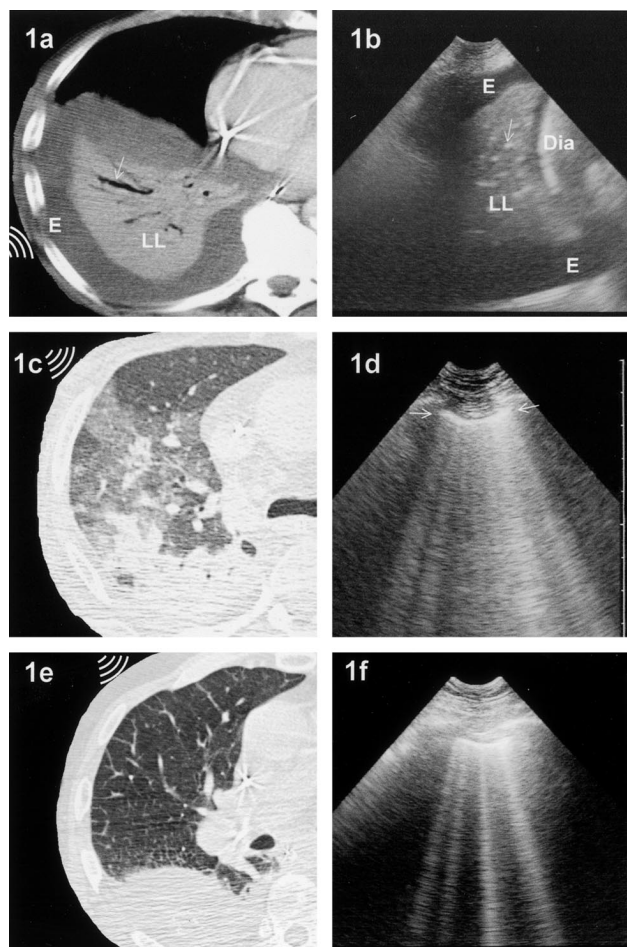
Computed tomographic and lung ultrasound aspects, respectively, of pleural effusion, alveolar consolidation, and alveolar-interstitial syndrome. (a,b) Fluid collection (E) delimited by the diaphragm (Dia) and the parietal and visceral pleura surrounding a consolidated lower lobe (LL) containing hyperechoic punctiform structures (air bronchogram; arrows). (c,d) Long comet tail artifacts arising from the pleural line (i.e., *B lines*) and multiple lung rockets at a distance of 3 mm or less and representative of ground-glass areas (pleural line; arrows). (e,f) Multiple comet tail artifacts (four *B lines*) at a distance of 7 mm and representative of thickened interlobular septa. The pattern is reminiscent of a rocket at liftoff, hence the practical term *lung rockets*.
